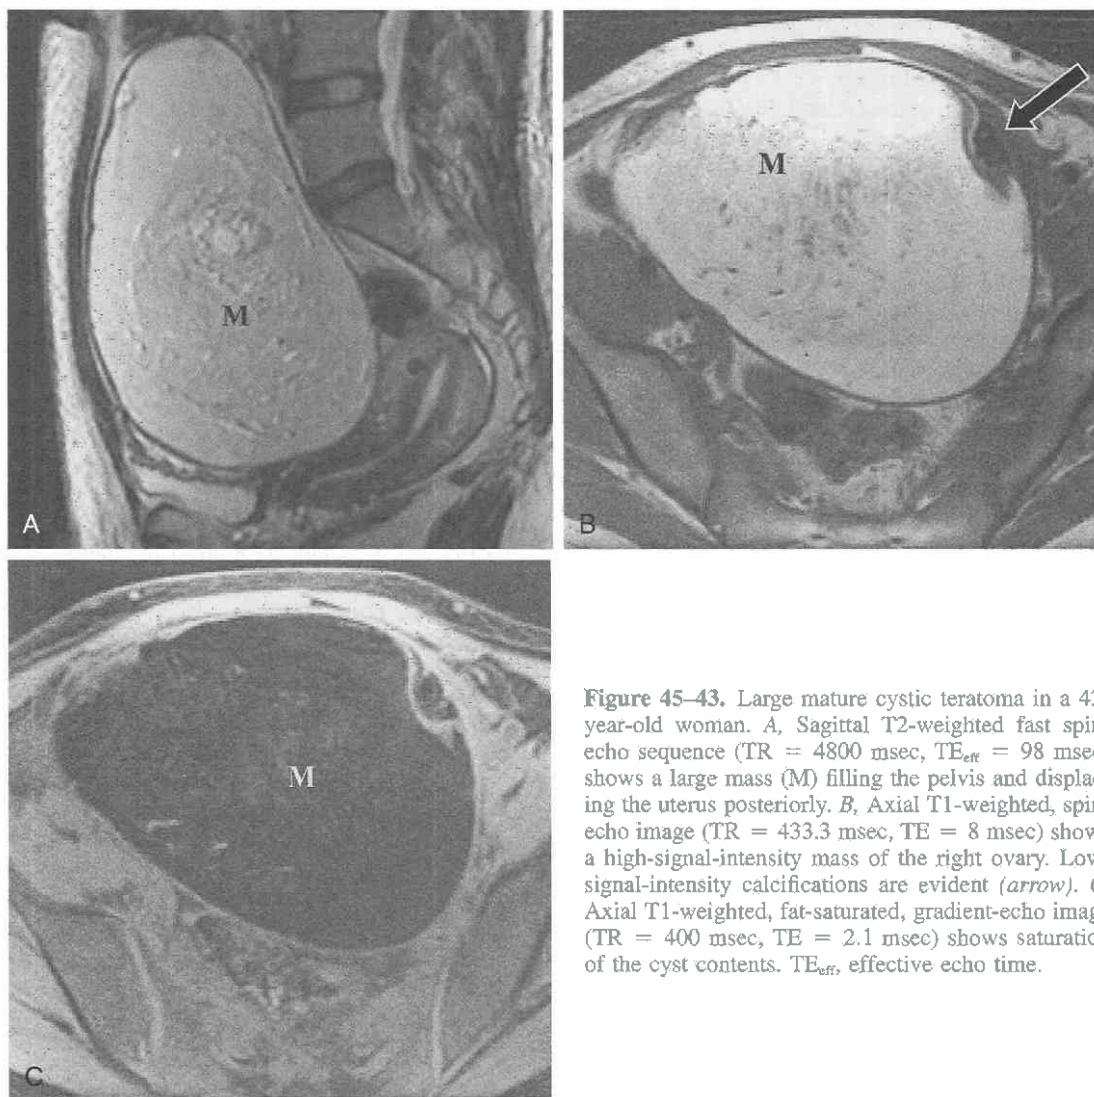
Large mature cystic teratoma in a 43-year-old woman. *A*, Sagittal T2-weighted fast spin-echo sequence (TR = 4800 msec, TE_{eff} = 98 msec) shows a large mass (M) filling the pelvis and displacing the uterus posteriorly. *B*, Axial T1-weighted, spin-echo image (TR = 433.3 msec, TE = 8 msec) shows a high-signal-intensity mass of the right ovary. Low-signal-intensity calcifications are evident (arrow). *C*, Axial T1-weighted, fat-saturated, gradient-echo image (TR = 400 msec, TE = 2.1 msec) shows saturation of the cyst contents. TE_{eff}, effective echo time.
